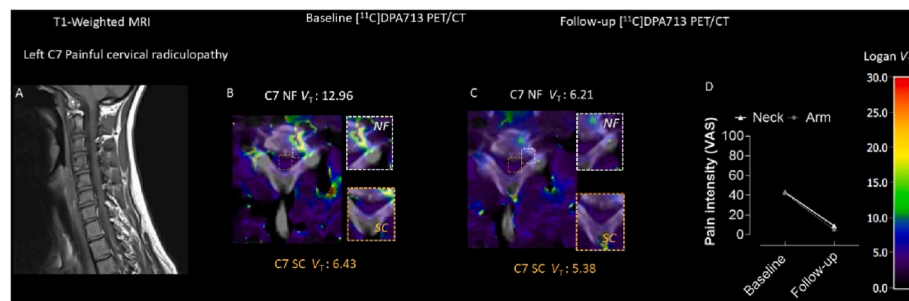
Neuroinflammation at baseline and after six weeks of neural tissue management (follow-up) in a patient with painful cervical radiculopathy. A: T1-weighted MRI. B: Baseline parametric cross-sectional image of $[^{11}\text{C}]\text{DPA713}$ binding merged with CT, with a zoomed view at the neuroforamina (NF) and spinal cord (SC). Higher volume of distribution (V_T) indicates more tracer binding, suggesting higher levels of neuroinflammation. C: Follow-up parametric cross-sectional image of $[^{11}\text{C}]\text{DPA713}$ binding merged with CT, with a zoomed view at the neuroforamina (NF) and spinal cord (SC). D: Baseline and follow-up pain intensity measured using pain visual analogue scale (VAS) for 24-h mean neck pain and arm pain.
